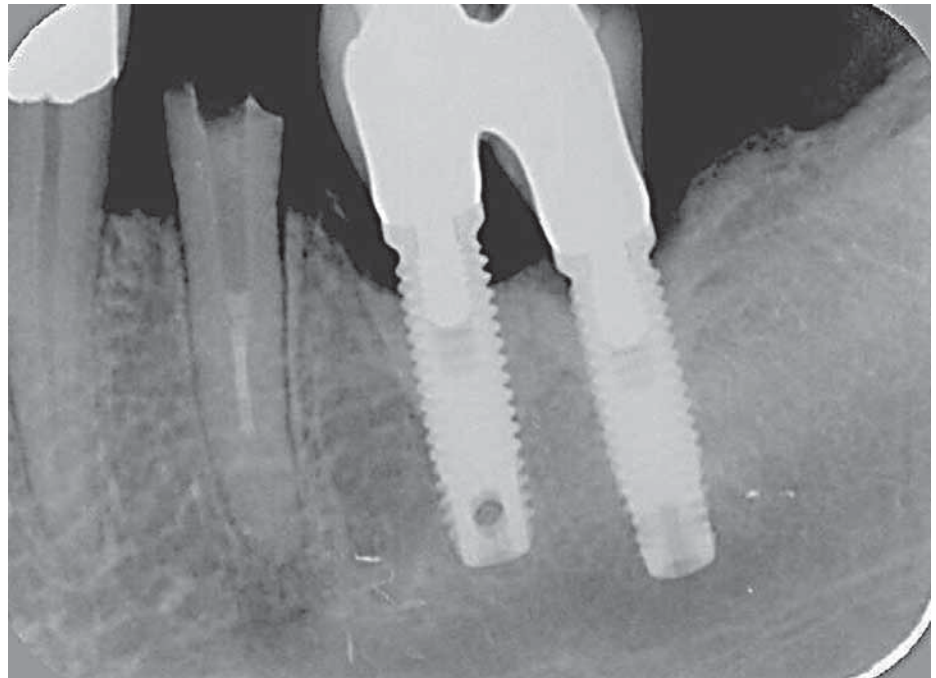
The patient complained about the decementation of a cast post and core from the lower left mandibular second premolar. The periapical radiograph shows the presence of a periapical radiolucency associated with a deficient root canal treatment.
